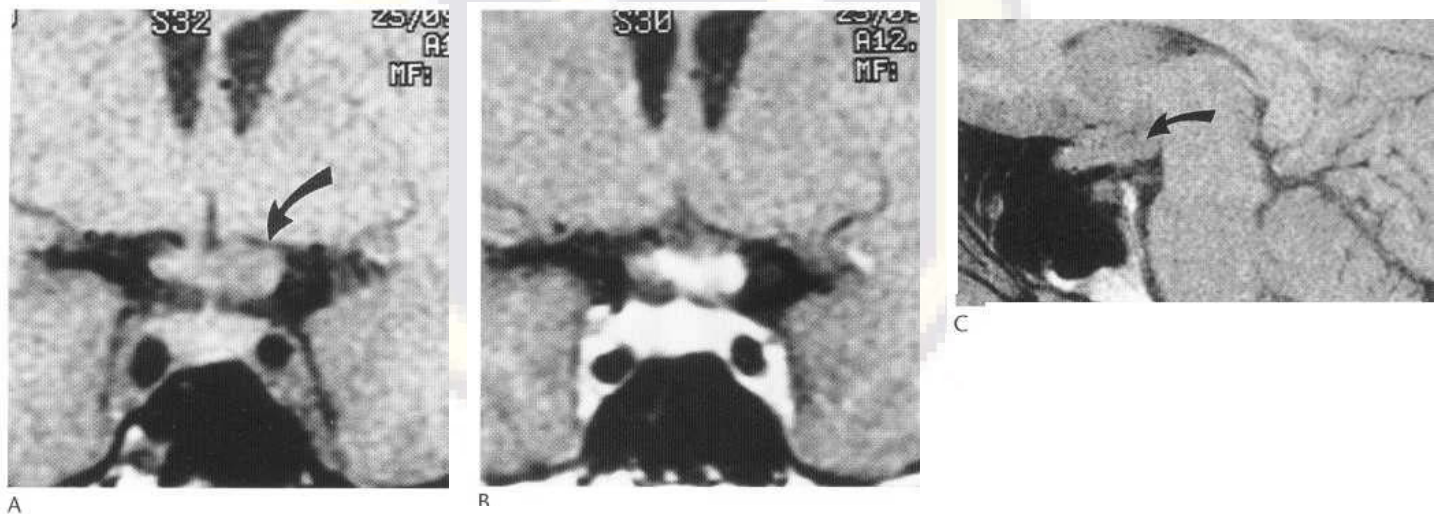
(A) Coronal MRI section through suprasellar cistern and sella shows chiasm swollen mainly on left side (arrow). The infundibulum is also seen. (B) Postgadolinium the tumour enhances, mainly on the left. (C) Left parasagittal section through the swollen chiasm (arrow).
